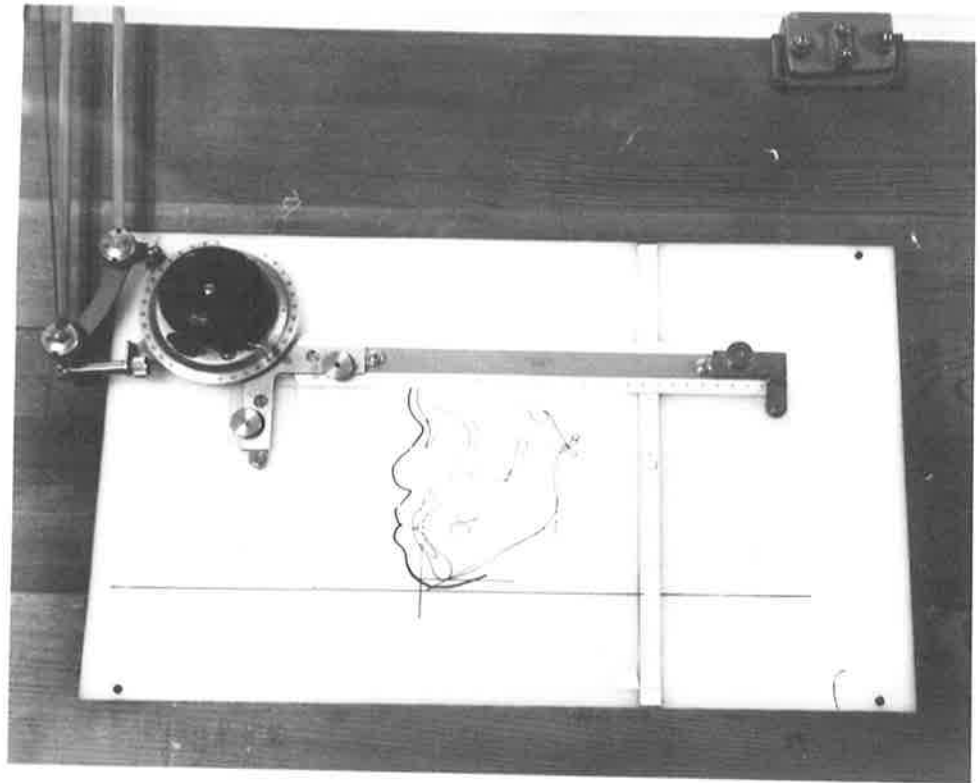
Closer view of parallelogram drafting machine showing specially constructed cursor attached to movable abscissa scale, which rides over tracing of roentgenogram and ordinate scale embedded into viewing screen. Cross-hairs were located over landmark and coordinates read from ordinate and abscissa scales.
